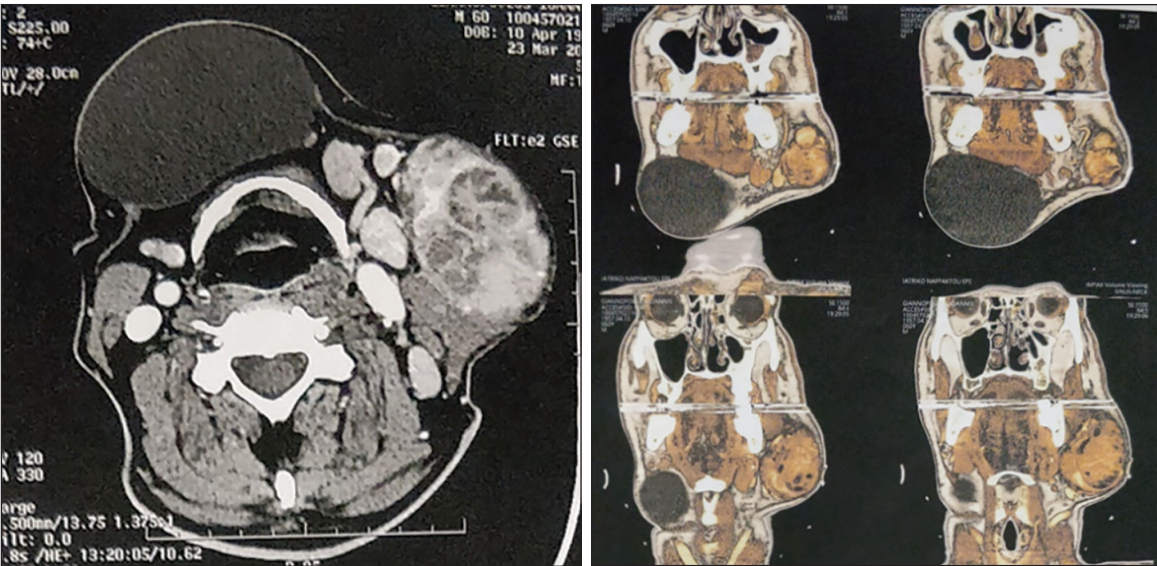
Preoperative imaging evaluation. CT scan showing the submental mass and the tumor in left parotid gland.
